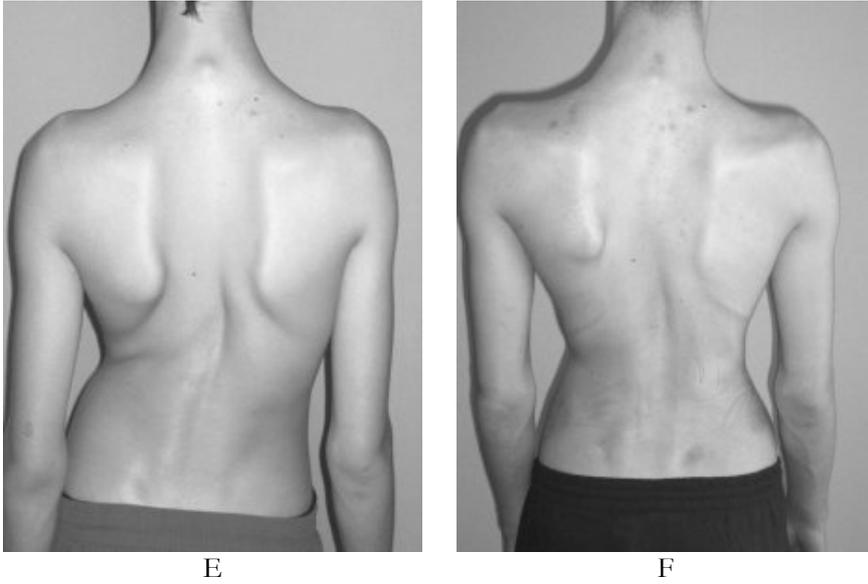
Case history of Simone. In each radiograph month and year are represented, as well as Cobb degrees. Bracing time is shown: 23/24 means 23 hours per day.
